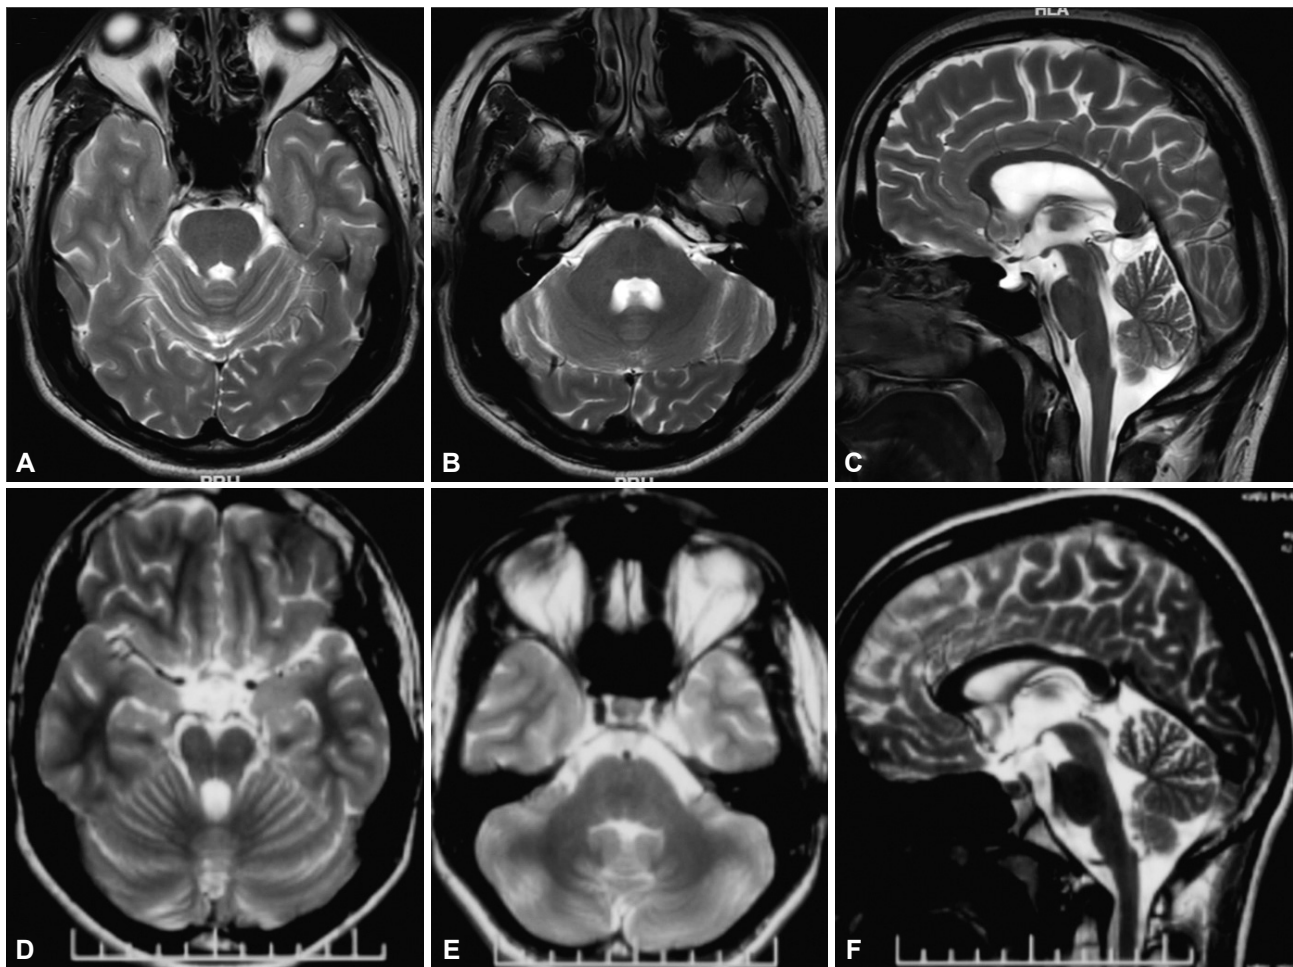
Brain MRI of two cases described in this report. Brain MRI of case 1 showing normal cerebellum and cerebellar peduncles (A-C). Brain MRI of case 2 showing atrophy of cerebellar vermis (D, F) and superior (D) and middle (E) cerebellar peduncle.
